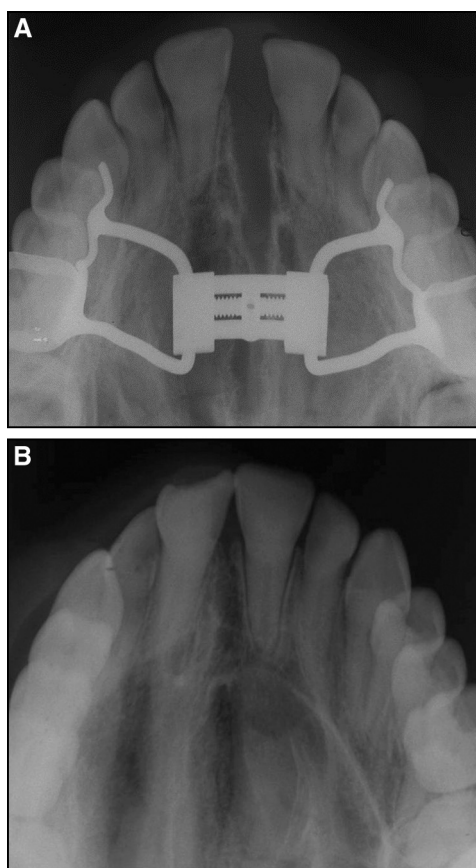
Occlusal radiographs in patient 3: A, after active RME treatment; B, 1 year from the end of active expansion therapy.
